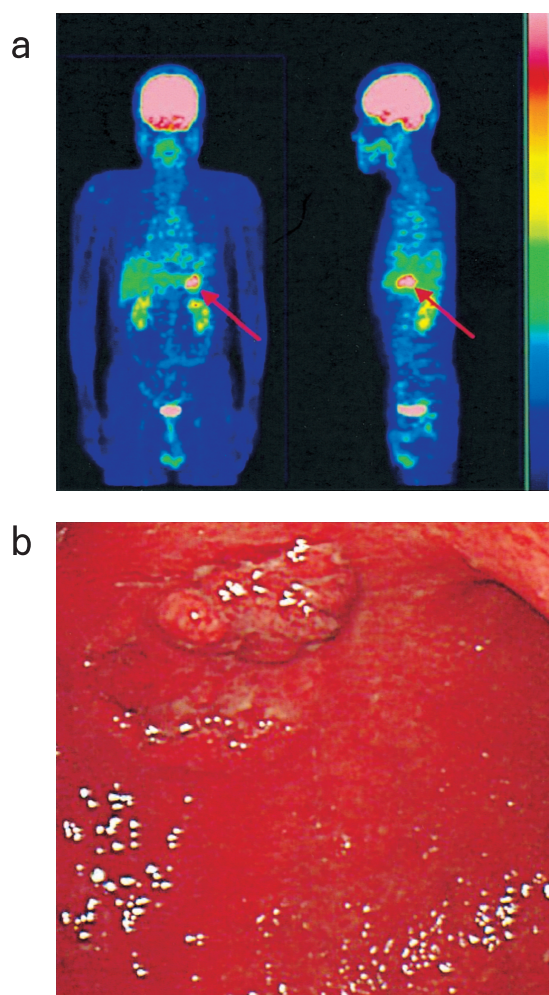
a An accumulation of FDG was observed in the middle gastric part, and the level of SUV was 4.68 (delayed imaging 3.34, Max).
